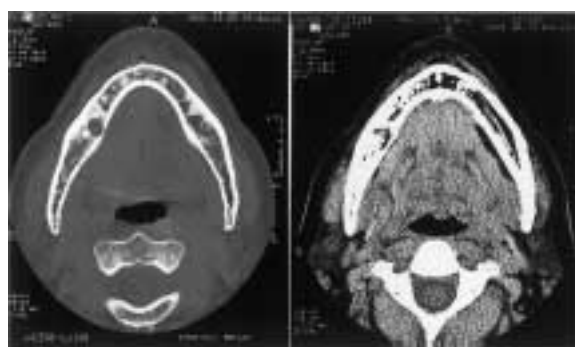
CT image (Axial scan).
